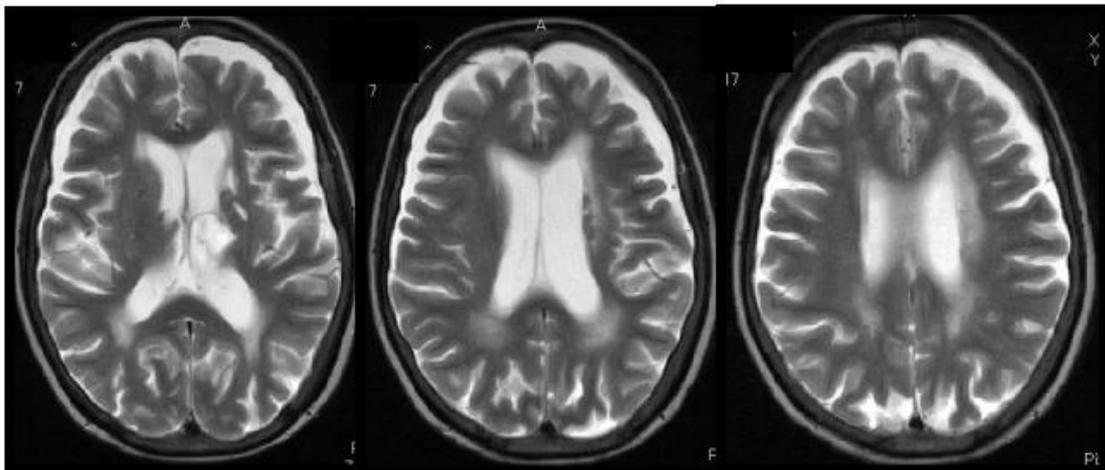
Pre-treatment T2-weighted MRI of case 2, who received WBRT+SRS
